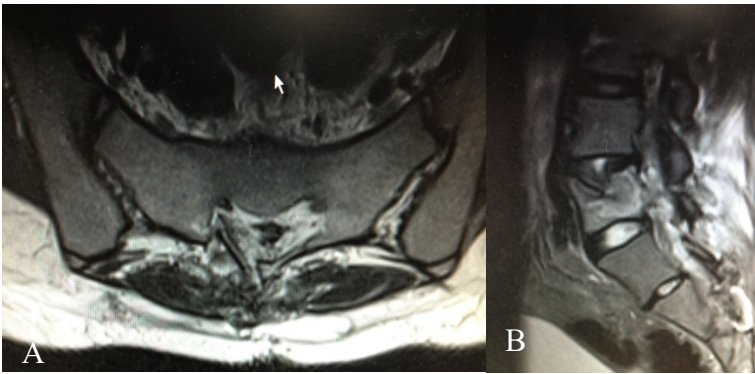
(A,B) axial and sagittal postoperative MRI showed L4 fracture without loss of body height or lumbar alignment and complete sacral canal decompression.
